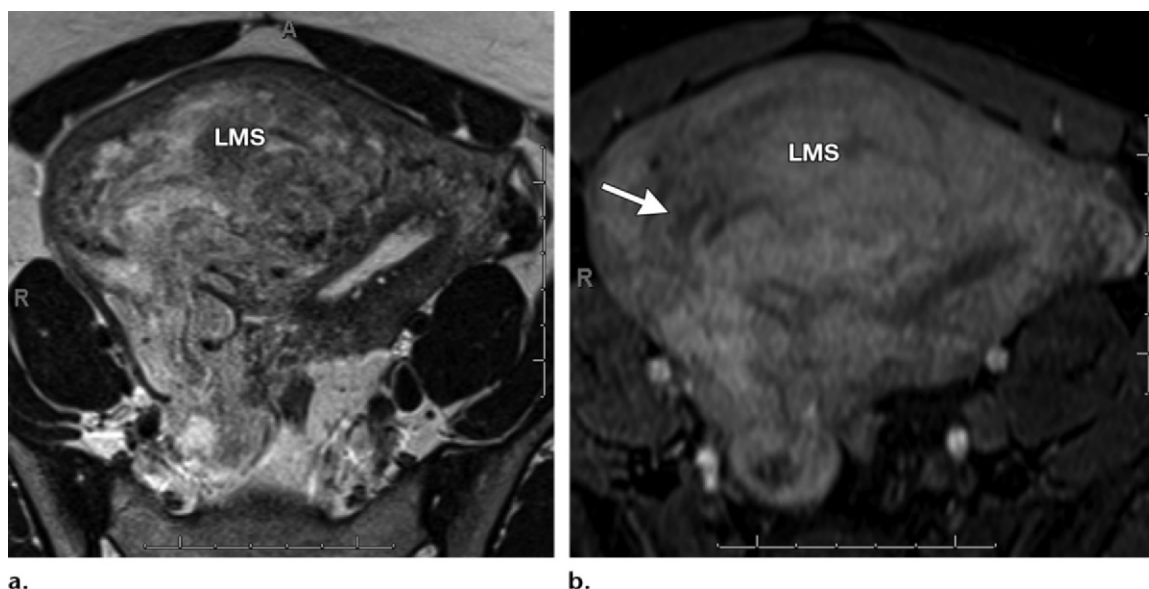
Uterine leiomyosarcoma in a 48-year-old woman. Axial T2-weighted (a) and contrast-enhanced fat-suppressed T1-weighted GRE (b) images show an enlarged uterus containing a heterogeneous mass (*LMS*) with poorly defined margins and internal necrosis (arrow in b). Pathologic analysis demonstrated that the mass was a leiomyosarcoma.
